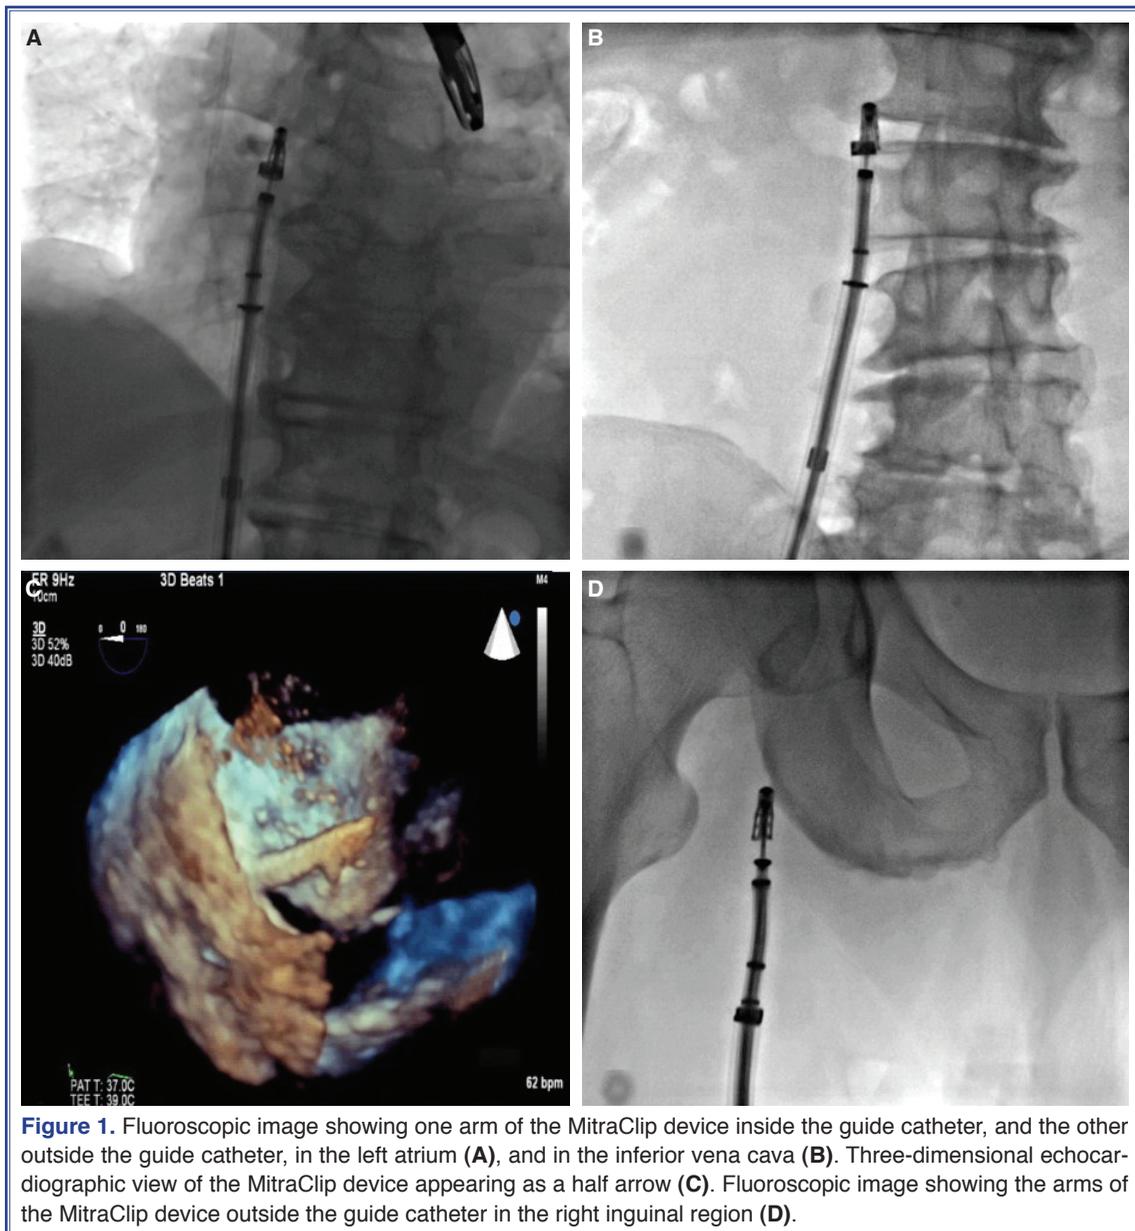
Fluoroscopic image showing one arm of the MitraClip device inside the guide catheter, and the other outside the guide catheter, in the left atrium (A), and in the inferior vena cava (B). Three-dimensional echocardiographic view of the MitraClip device appearing as a half arrow (C). Fluoroscopic image showing the arms of the MitraClip device outside the guide catheter in the right inguinal region (D).
